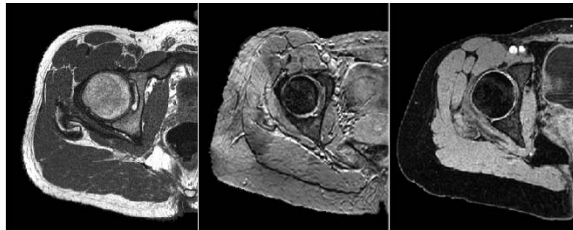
Different MRI sequences for imaging the hip: a) Spin-Echo T1 b) Gradient-Echo T2* c) Gradient-Echo T1
